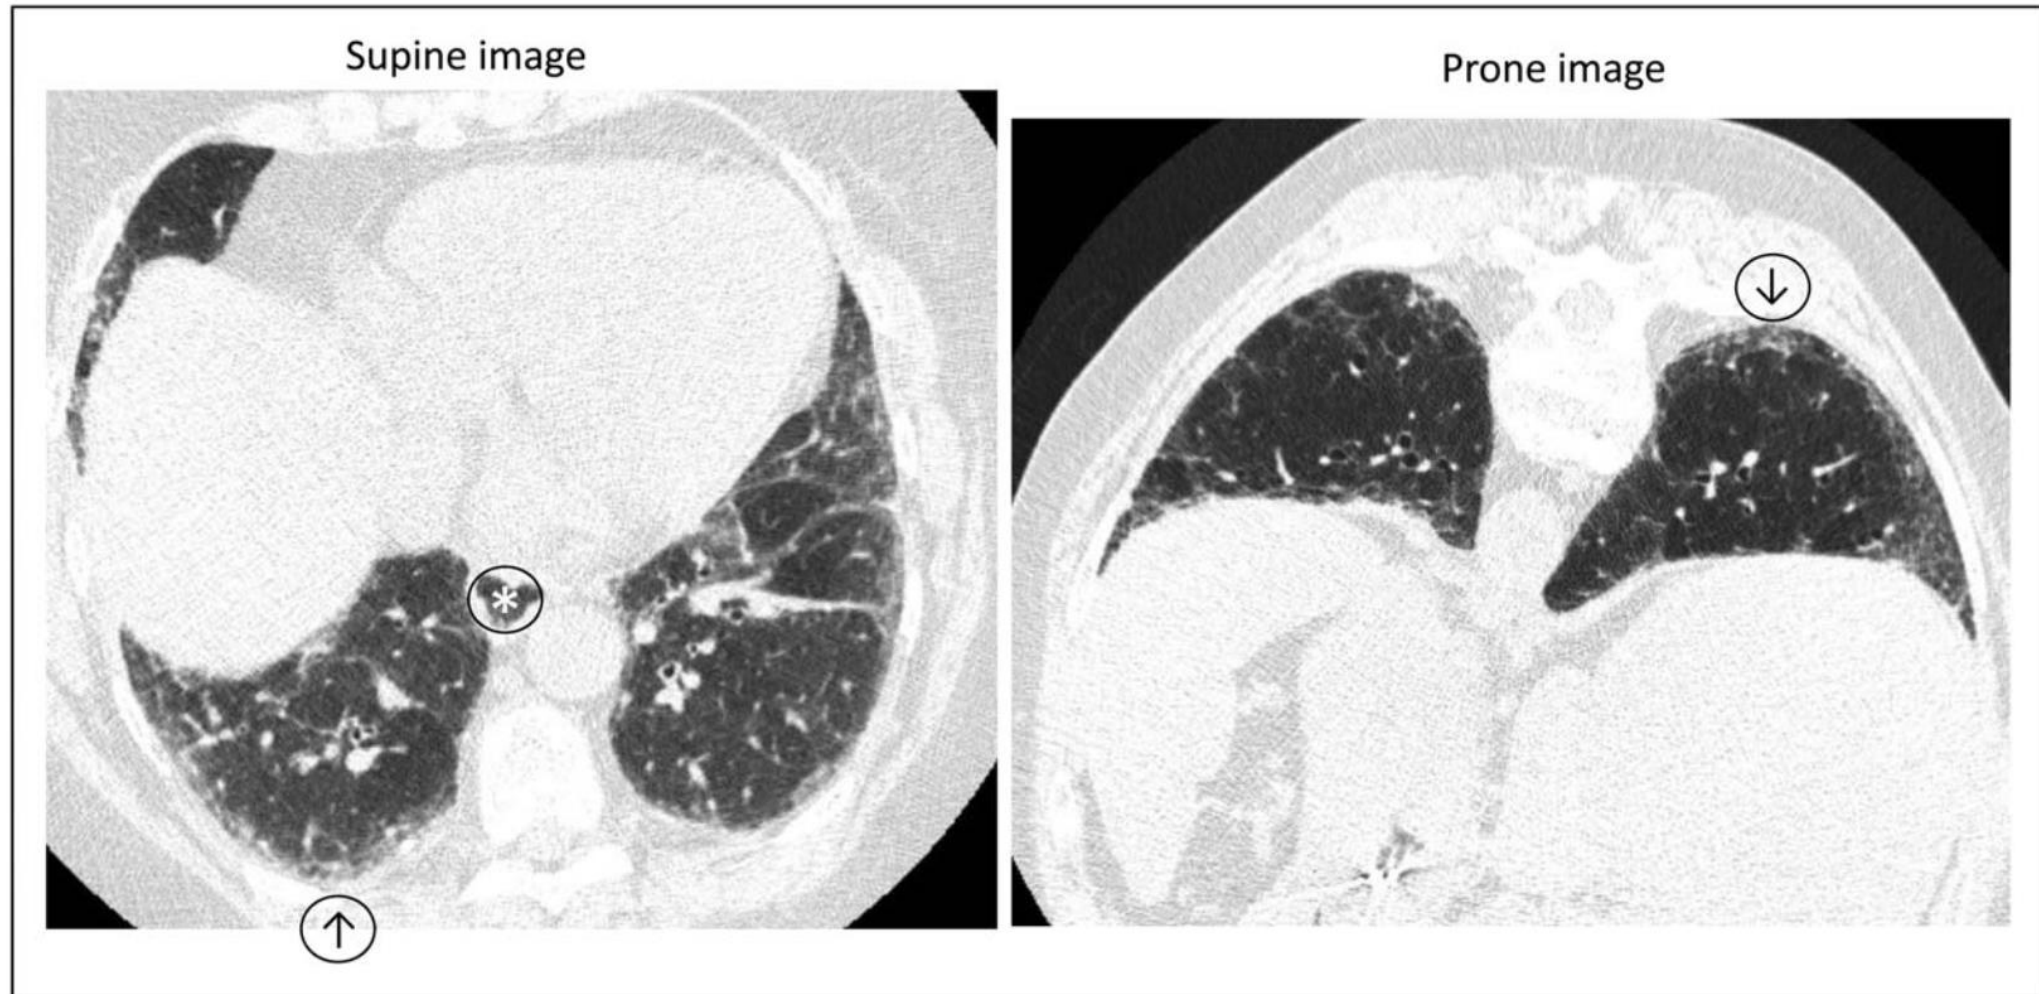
High-resolution CT in systemic sclerosis-interstitial lung disease. Inspiratory and prone HRCT demonstrating minimal reticulation, subpleural ground glass opacity (↑) that persists on prone imaging (↓) suggestive of interstitial lung abnormalities and an early fibrotic lung disease. No honeycombing or traction bronchiectasis. *Note slightly dilated esophagus. CT, computed tomography; HRCT, high-resolution CT.
